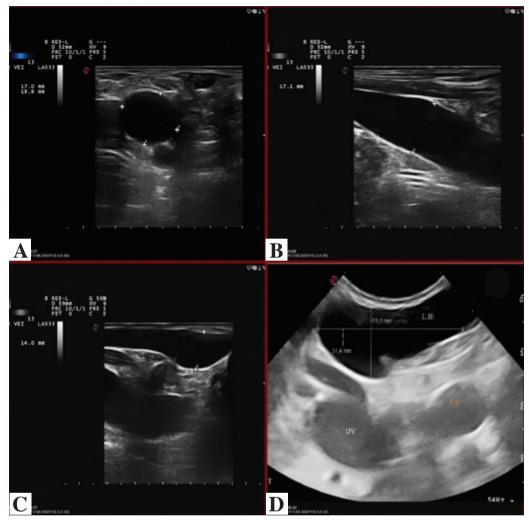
Ultrasonographic images of left-sided distended internal-external jugular veins and right-sided vascular sac. A. Left-sided internal jugular vein measuring ≤18 mm on transverse plane. B. Left-sided internal jugular vein measuring ≤17 mm (maximum size) on longitudinal plane. C. Right-sided vascular sac measuring 14 mm in thickness on longitudinal plane. D. Left-sided vascular sac vein measuring ≈13 x 31 mm.
